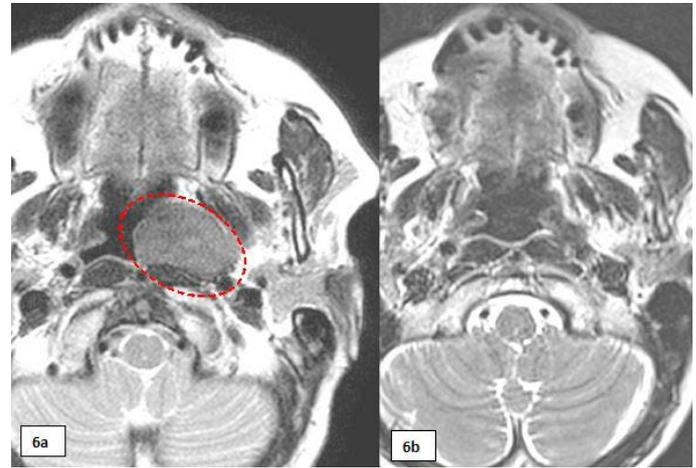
Magnetic resonance (MRI) scan acquired in Patient 5 reveals nasopharyngeal tumor on the left—encircled with a dashed line (6a); whereas follow-up MRI scan one year after the procedure reveals no signs of amyloidosis recurrence.
